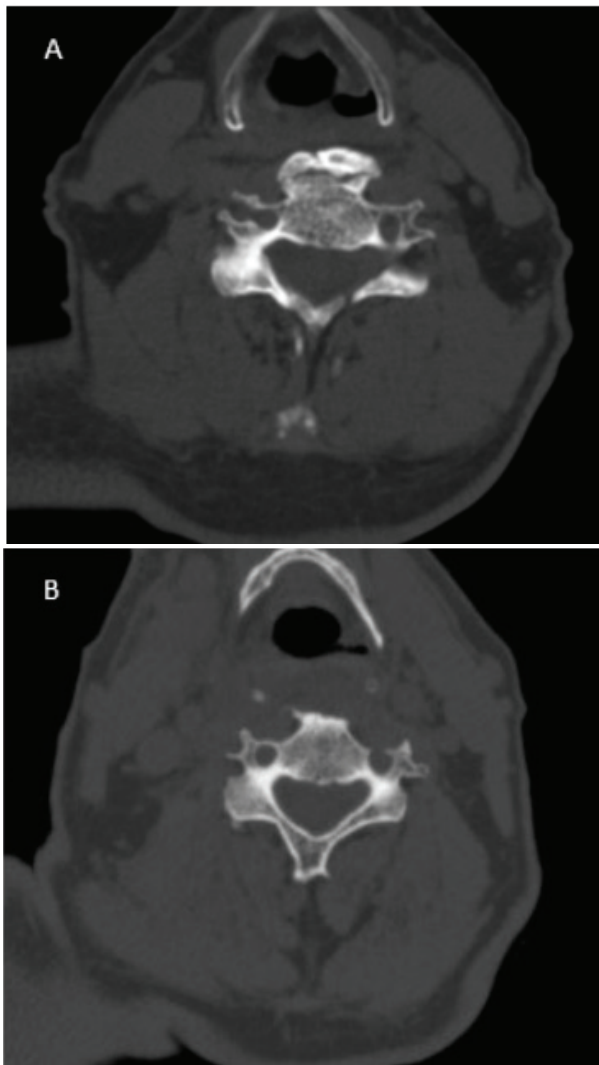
Preoperative (A) and postoperative (B) axial CT scans show total removal of anterior cervical osteophyte
